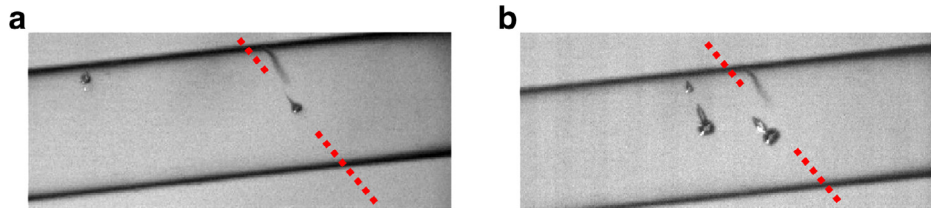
Top view images of initial microbubble cavitation response, at  $t \approx 11.4 \mu\text{s}$ , to a focused ultrasound burst of peak negative pressure = 1.5 MPa, with the propagation axis depicted by the red dashed line, for (a) a relatively isolated microbubble located centrally within the capillary, and (b) three microbubbles, two located centrally within the capillary and one closer to the wall. Flow within the capillary is left to right. Scale is provided by the internal diameter of  $500 \mu\text{m}$ , and a flaw on the capillary (*white arrowhead*) acts as a convenient fiducial.
